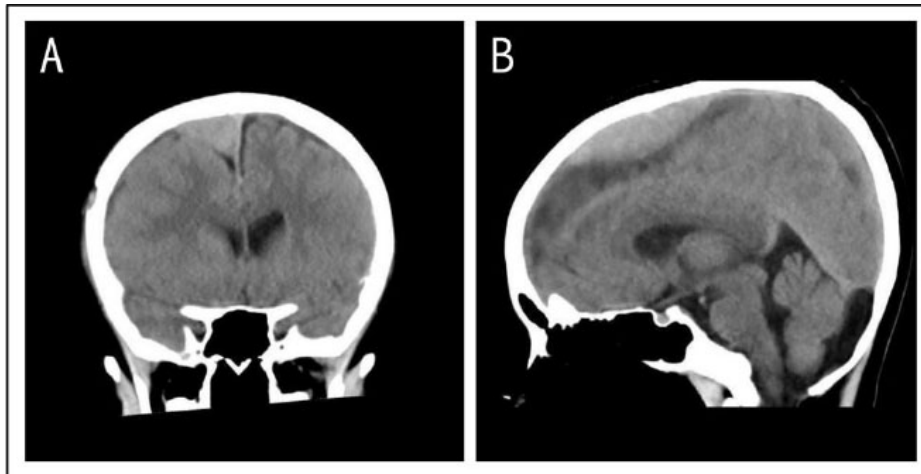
Head computed tomography scan showing acute subdural hematoma on the right parasagittal lobe. A: Coronal, and B: Sagittal slice.
